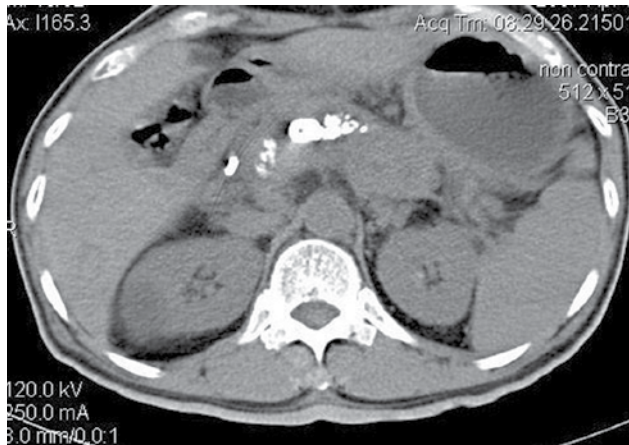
CT scan of the abdomen demonstrated calcification in the main pancreatic duct in area of neck and body.
